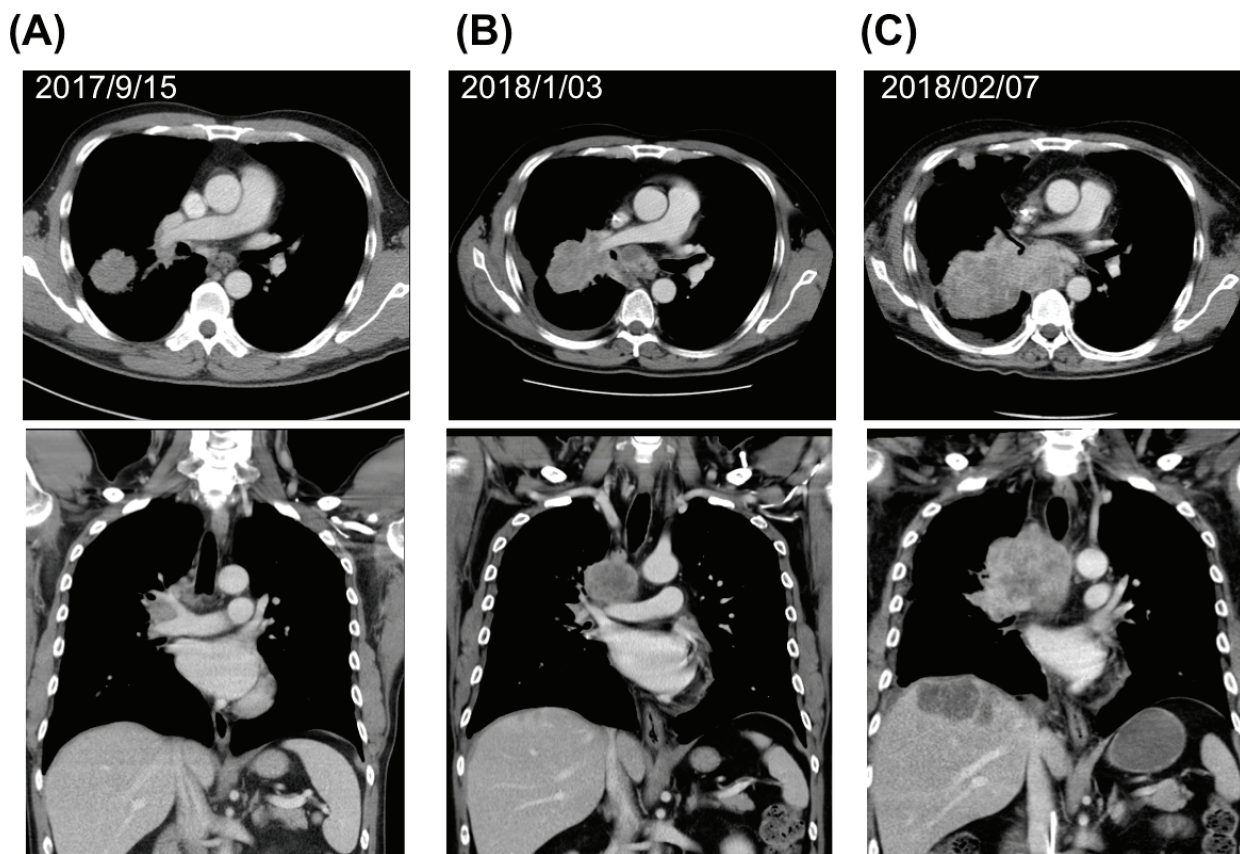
Serial chest contrast CT scan showing changes in the patient's primary lung cancer and metastatic site from initial diagnosis (A), to after crizotinib treatment for 60 days (B), and after treatment with pembrolizumab combined with docetaxel (C).
